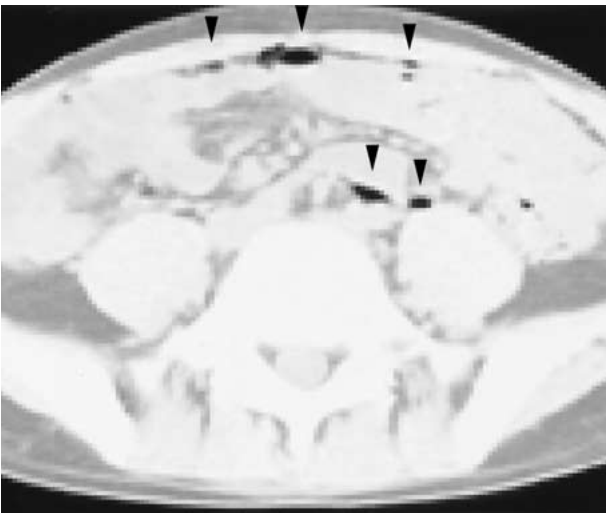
Small amounts of air at the anterior abdominal surface and in the retroperitoneum (*arrowheads*). The presence of air is more confidently identified on a CT image with a wide window setting than with a conventional window setting.
